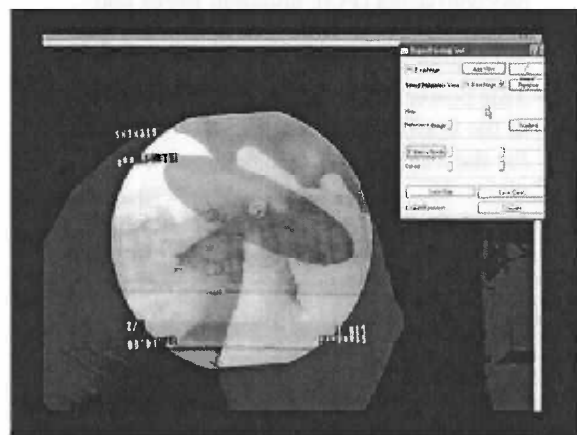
merged x-ray/video-image during transpedicular needle placement
